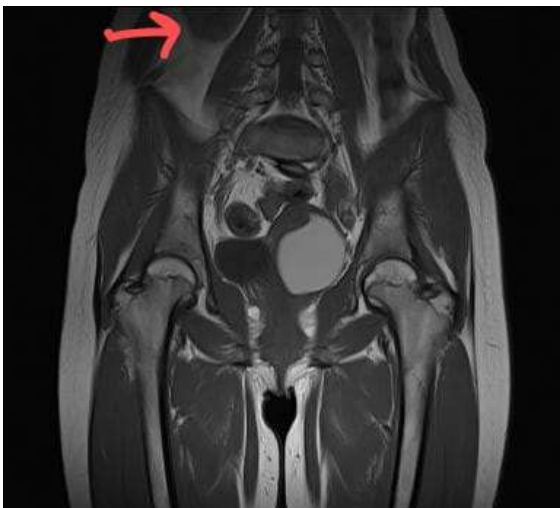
MR image showing a right renal lower pole in T1 coronal section, but no left kidney.
